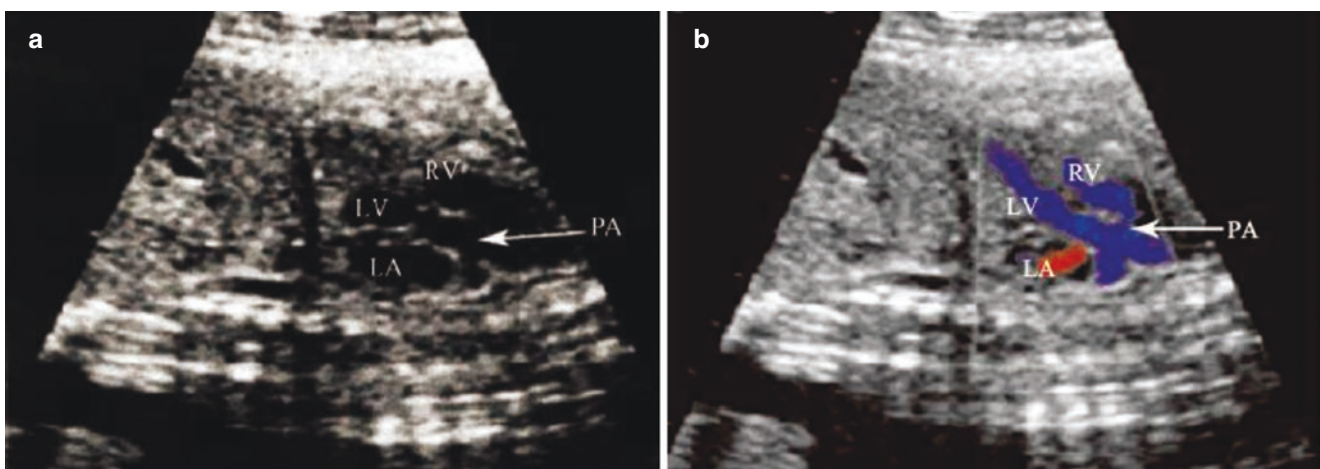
Transposition of great arteries. (a, b) A nonstandard view of the long axis of the LV shows 2-D and color Doppler flow imaging shows ventricular arterial discordance with atrioventricular concordance, indicating d-TGA
